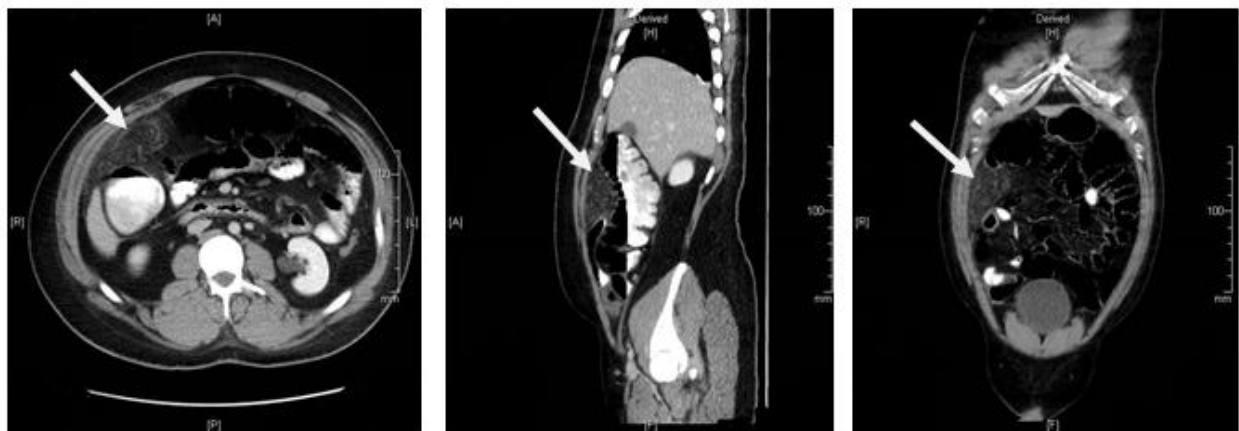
A CT scan images of abdomen upon discharge.
